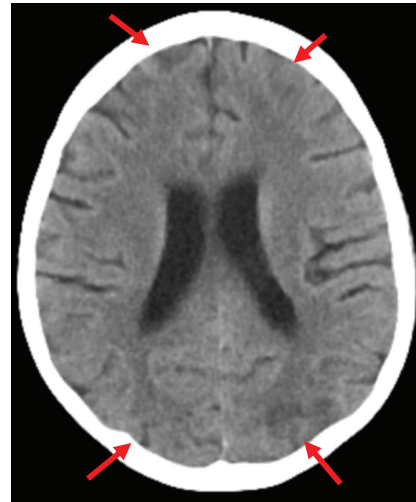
Brain CT scan with hypodense, bilateral, symmetrical cortical-subcortical posterior parietal and frontal lesions that could be in the context of Posterior Reversible Encephalopathy Syndrome (PRES). Red arrows show the affected areas.
